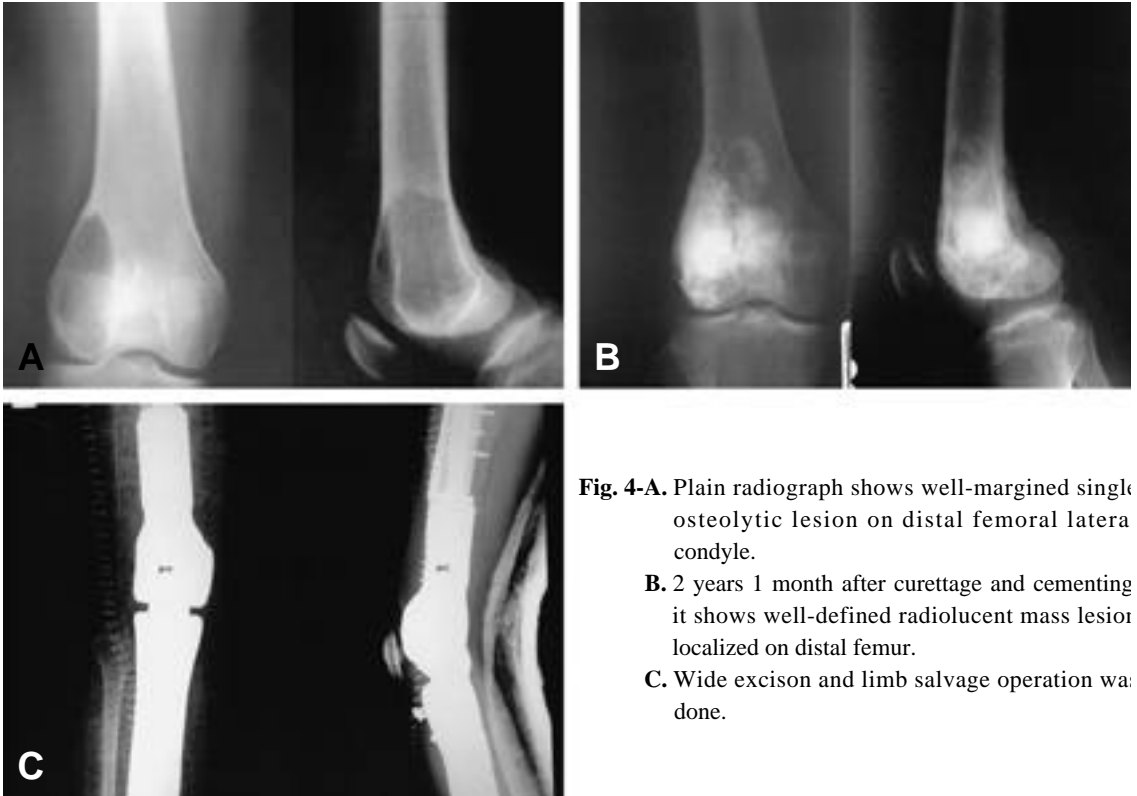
Plain radiograph shows well-margined single osteolytic lesion on distal femoral lateral condyle.
